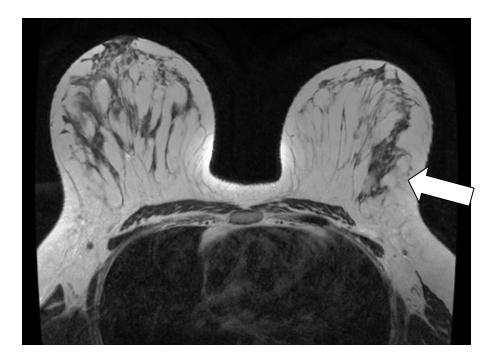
Sagittal T1 weighted MRI breast image on the 1 o'clock outer breast tissue
